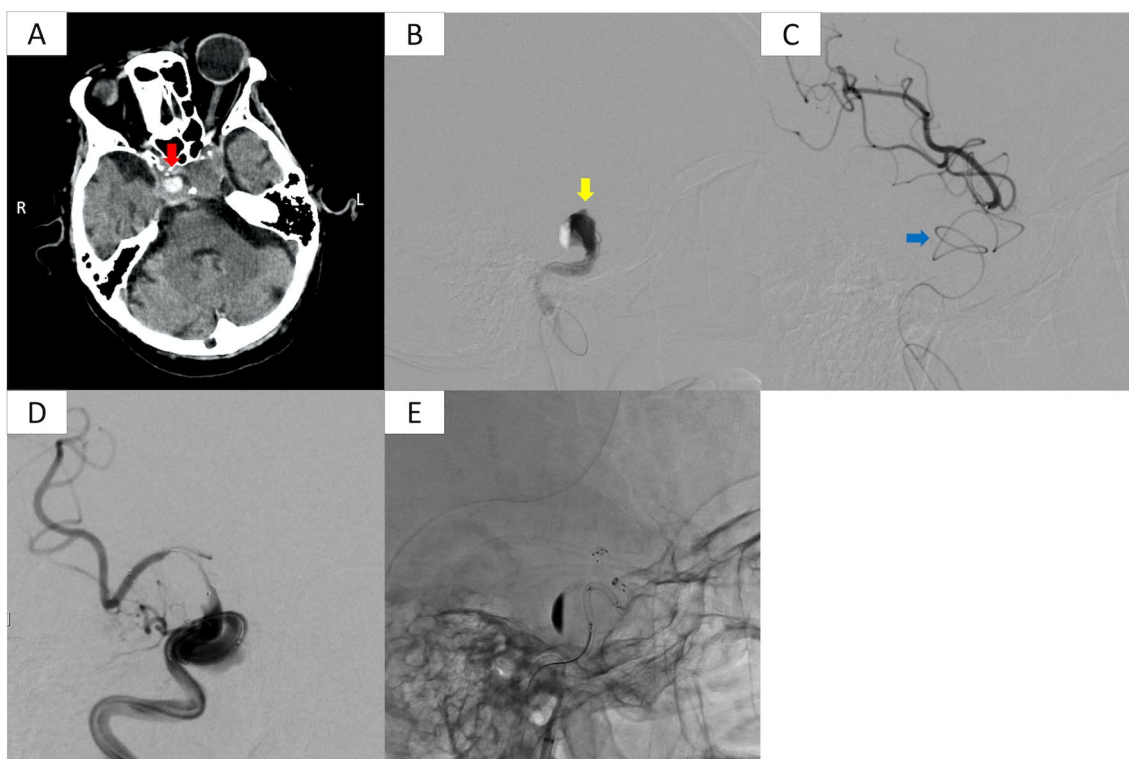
A Head CT image on admission. A thrombus was detected in the right-side large paraclinoid aneurysm (AN) on CT (solid red arrow). B Digital subtraction angiography at mechanical thrombectomy. Contrast stagnation was significant, which interfered with the creation of a roadmap and the visibility of the microwire and catheter. When multiple images were captured at different angles, the exit of the AN was detected as a notch (solid yellow arrow). C Microcatheter formed a loop within the AN and was guided distally (solid blue arrow). D Imaging during stent retriever deployment from the M1 to the ICA. E Catalyst 7 catheter was pulled up using the stent retriever as the anchor. It can be observed that the Catalyst 7 catheter in the AN was straightened
